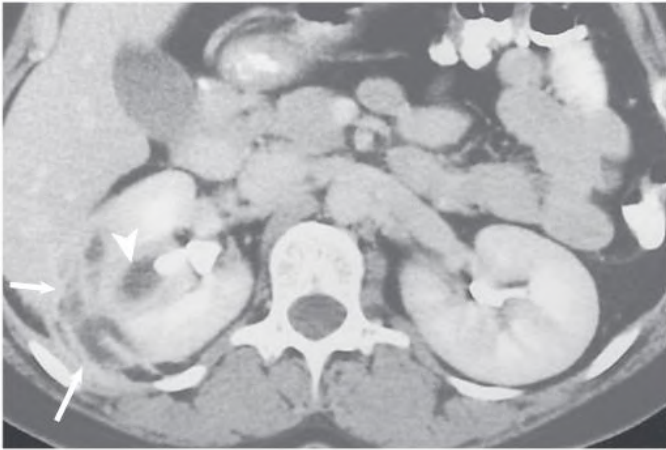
Renal Abscess. Contrast-enhanced computed tomography scan shows an abscess in the medulla of the kidney (arrowhead) with penetration and extension into the perinephric space (arrows). (Courtesy L. Townner.)
